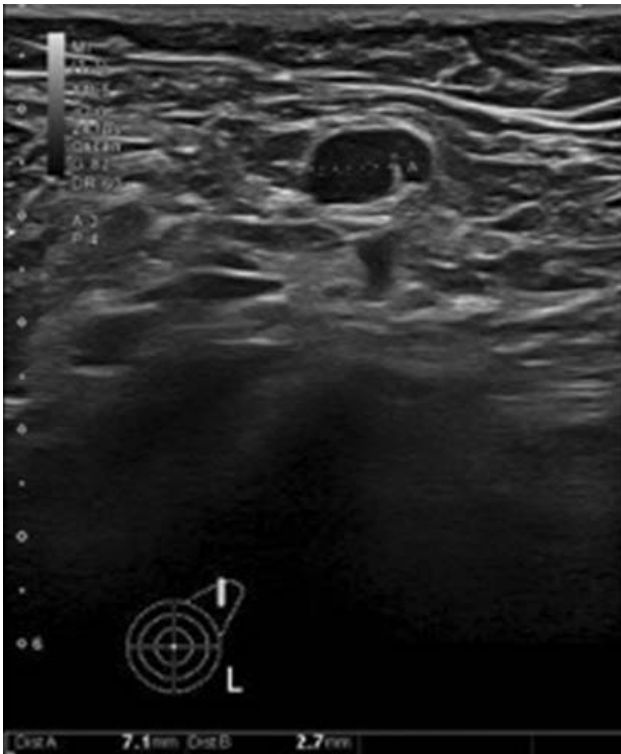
Left axillary ultrasound shows eccentrically thickened cortex measuring 7.1mm and displaced hilum
